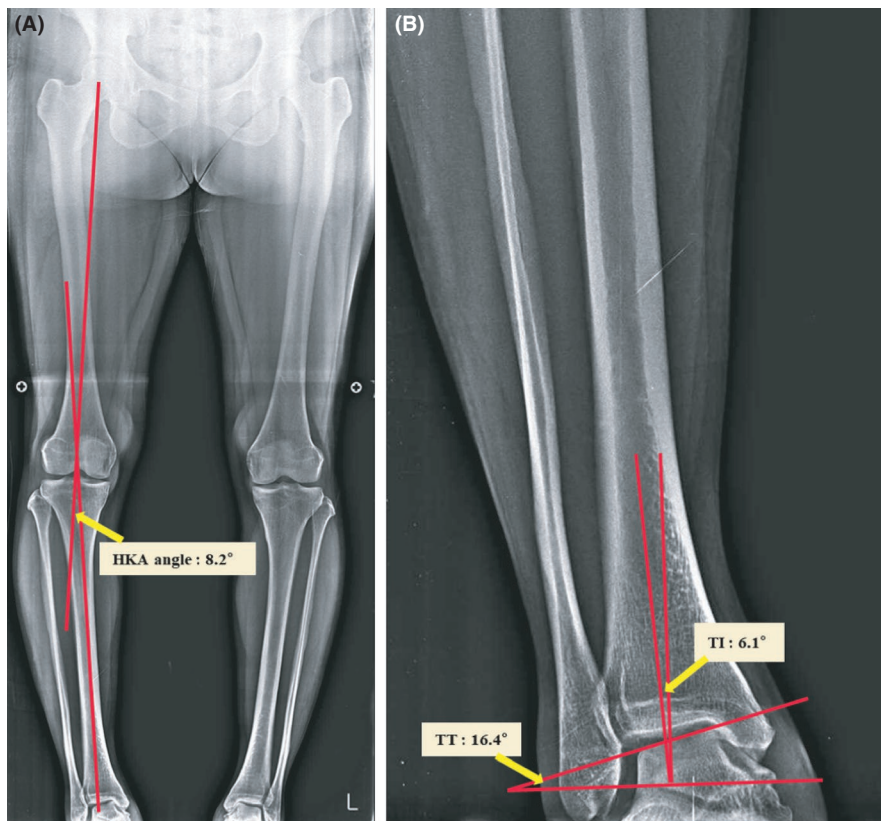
Before HTO. Whole leg radiographs of a 48-y-old woman in the standing position. A, Hip-knee-ankle (HKA) angle: the angle between the femoral and tibial mechanical axes in the anteroposterior view. B, Talar tilt (TT): the angle between the tangent of the superior talar surface and the horizontal line. Tibial inclination (TI): the angle between the tibial axis and the perpendicular line
